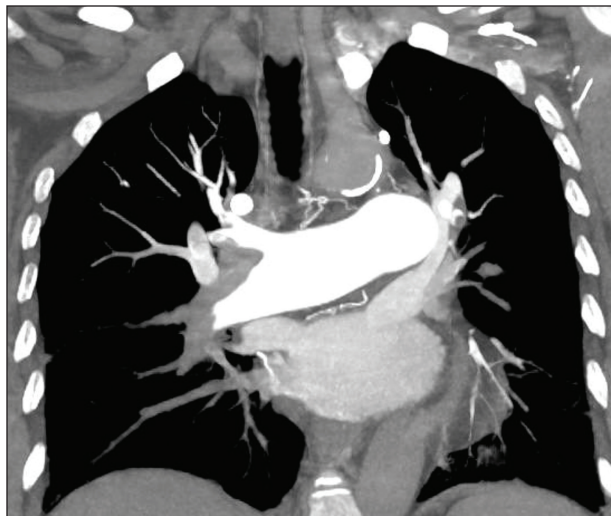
CT pulmonary angiogram revealed significant bilateral acute PE.
